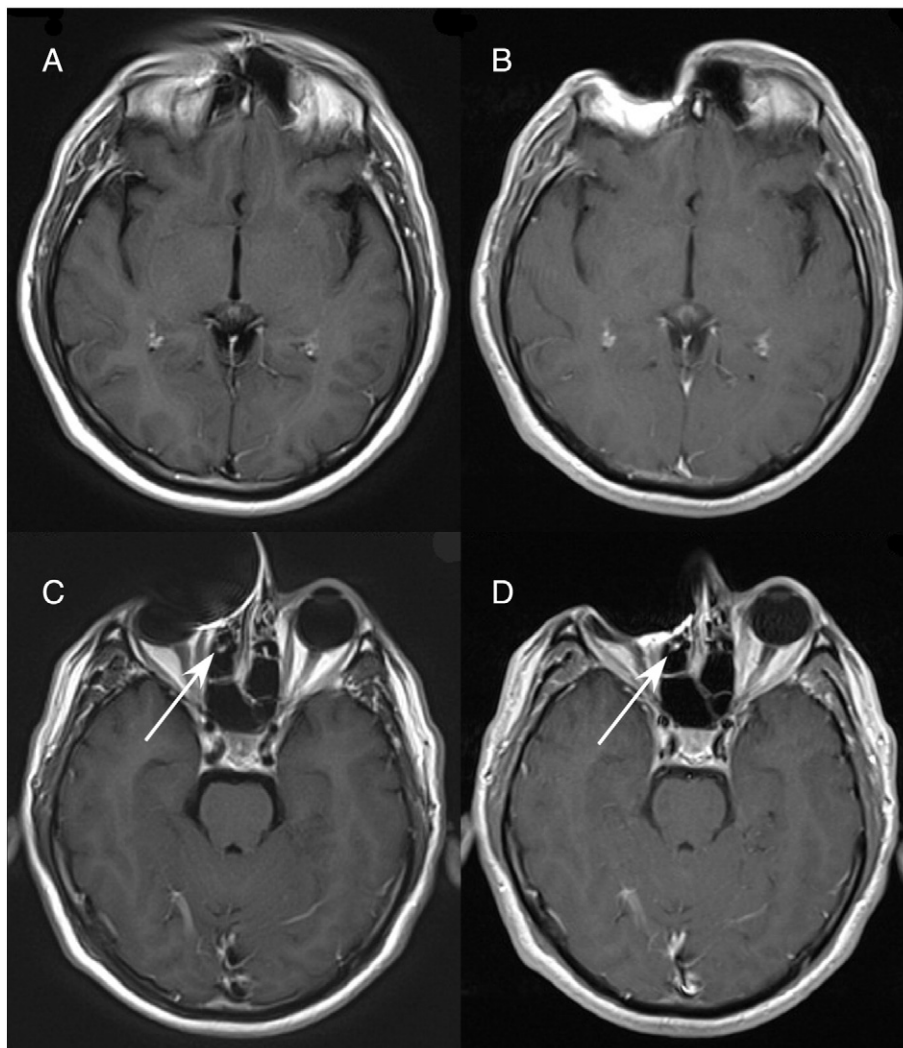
Sequences: T1W FLAIR BLADE (A, C), T1W SE (B, D). T1W FLAIR BLADE reduces susceptibility artifacts and offers a better imaging of the facial bones and the orbit.
